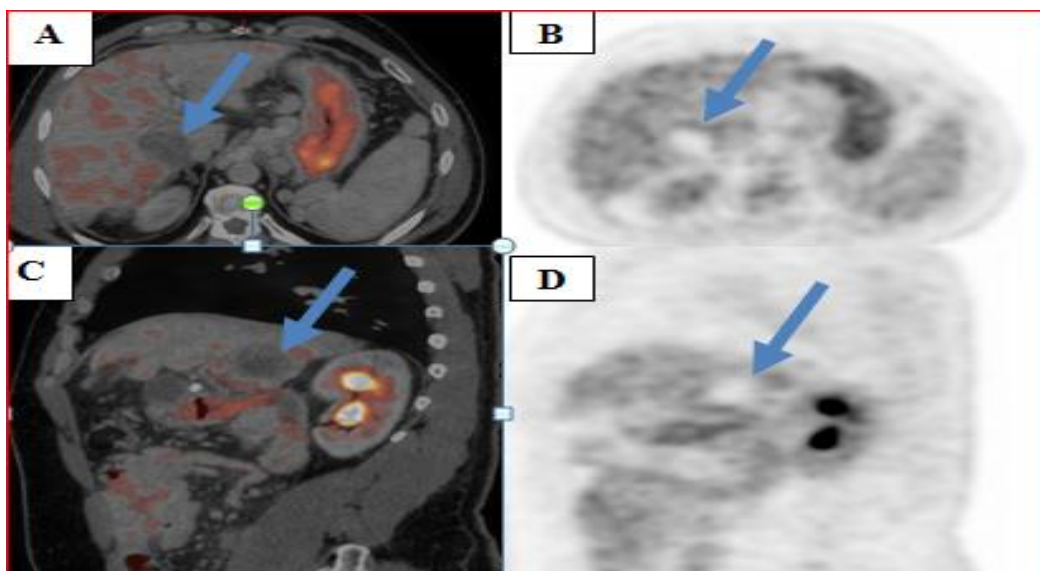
49 years old male patient with history of HCC diagnosed with typical enhancement criteria of HCC by triphasic CT and elevated alpha fetoprotein (98ng/ml) underwent radiofrequency ablation, referred for PETCT 1 month after RFA.
